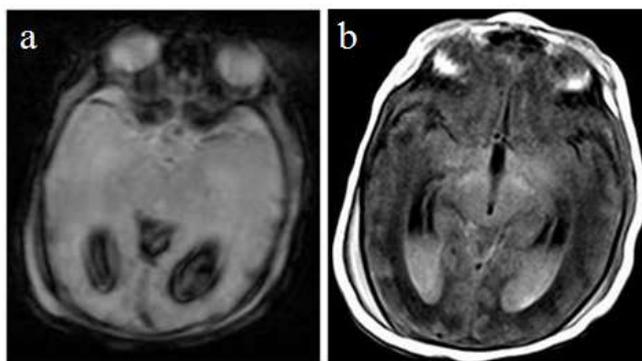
Axial MR images at the level of lateral ventricles showing areas of altered signal intensity in periventricular areas posteriorly appearing hypointense on T1WI (a). These areas do not show restriction on DWI (b) suggestive of HIE.
